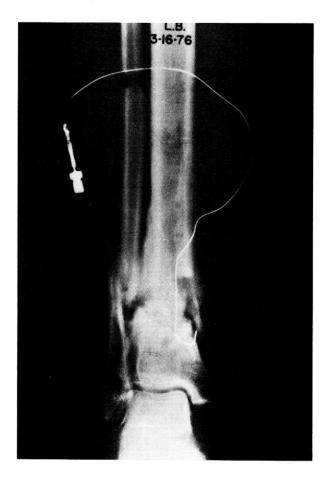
A radiograph after placement of a silver cathode into a tibial nonunion. The clear area in the proximal side is due to a slot that was made in the cortex to gain access to the site.
